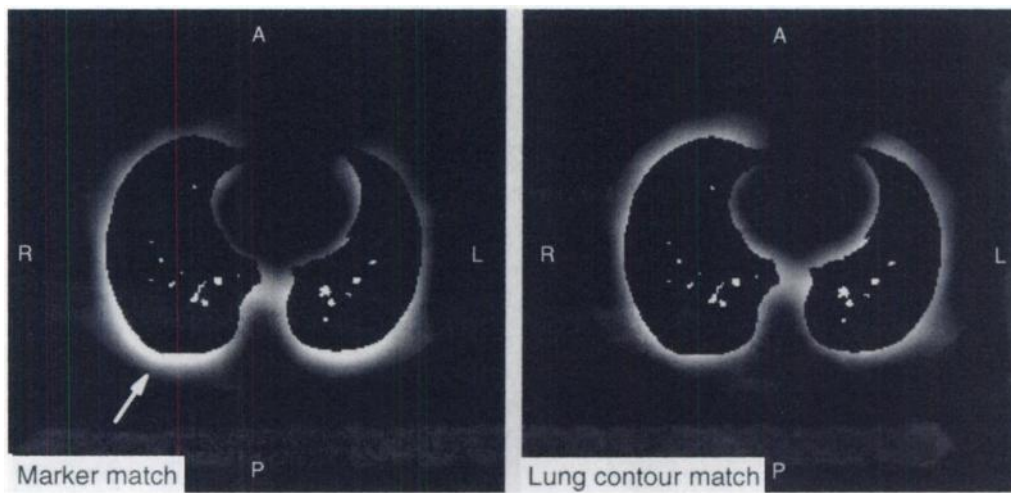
Transversal image of SPECT ventilation counts outside the CT-defined lung after CT-SPECT matching. (Left) Marker match. (Right) Lung contour match. Note the increased activity on the posterior side of the lungs (Left, white arrow).
